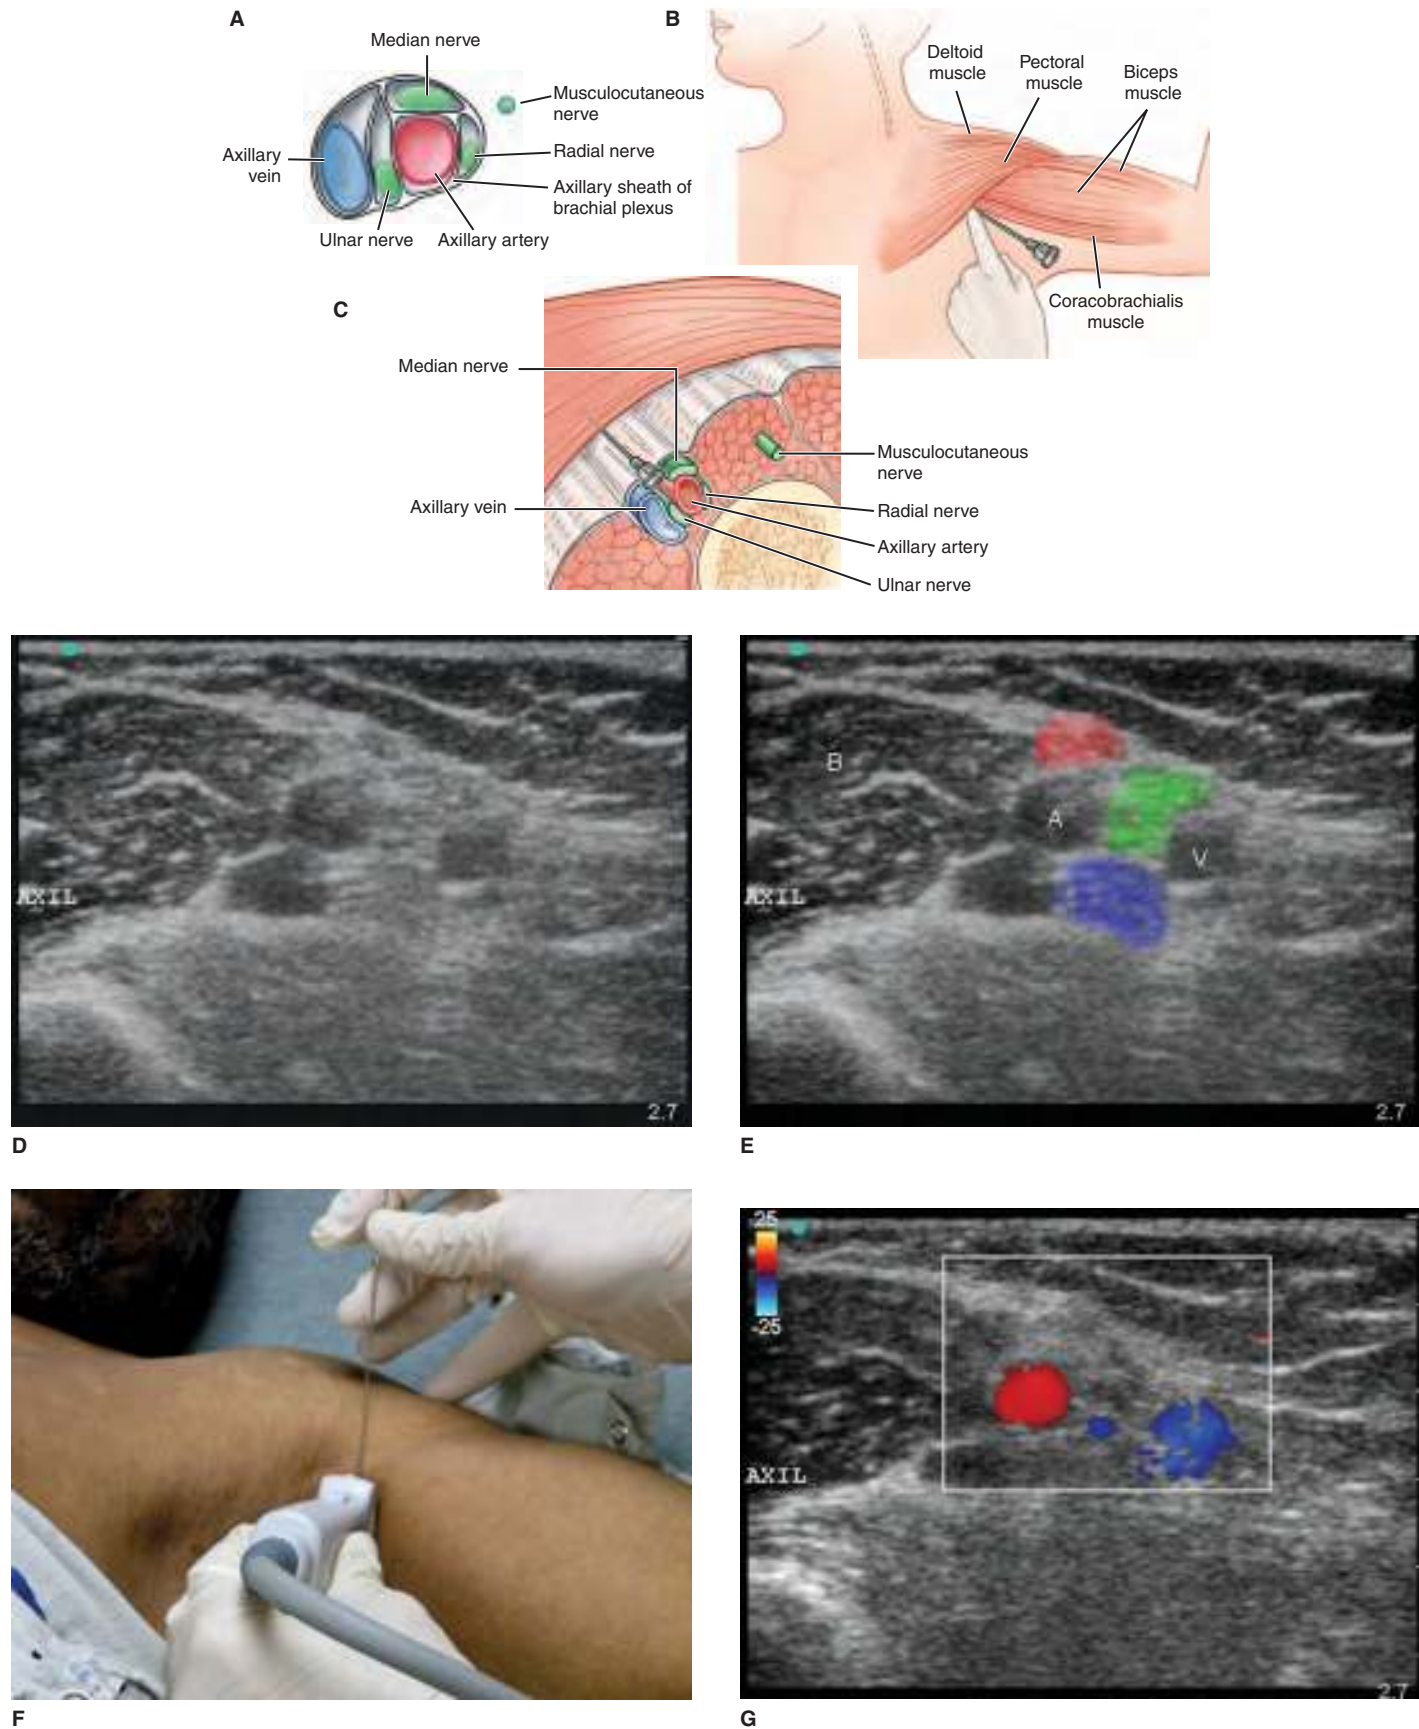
The axillary approach to the brachial plexus block. A. The topographical arrangement of the contents of the axillary sheath at the level of the blockade. B. The patient is positioned and the axillary artery pulse is palpated with one finger. The needle is inserted above the pulse and along the course of the axillary sheath. C. The needle may travel above the sheath and enter it at a higher level. D. US image of the axillary brachial plexus. E. Same image as in part D with labels (A, axillary artery; B, biceps muscle; V, axillary vein; red oval, median nerve; green oval, ulnar nerve; blue oval, radial nerve). F. US transducer and needle placement. G. Color Doppler of the axillary artery (red) and vein (blue).
